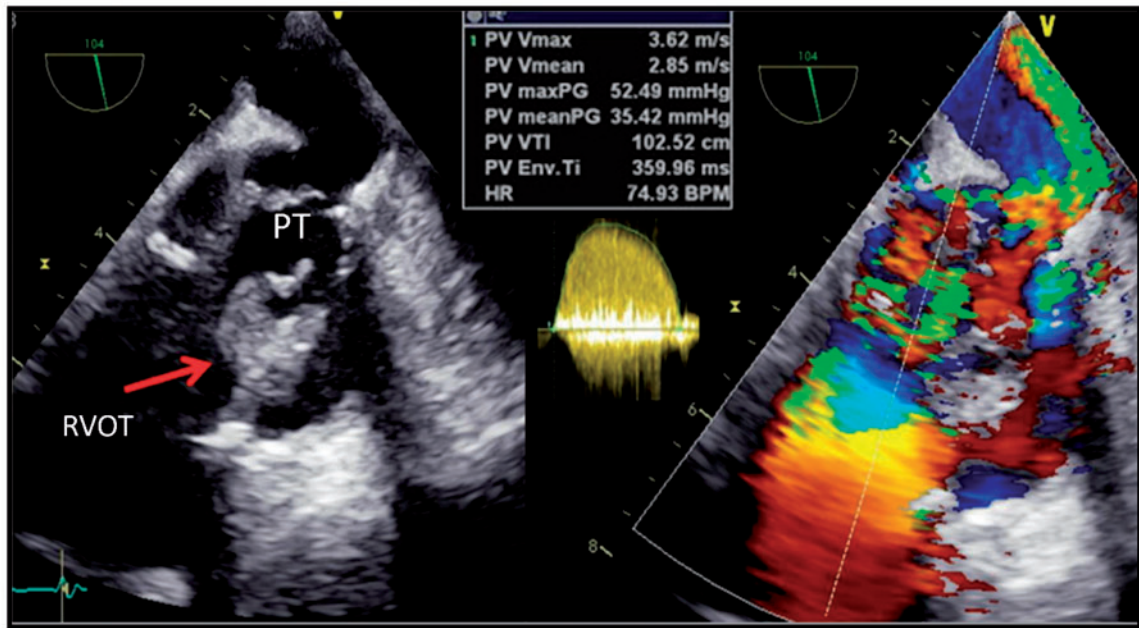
Transoesophageal echocardiogram. Red arrow pointing to a mobile mass arising from the arterial side of the pulmonary prosthesis, extending into the right pulmonary artery and causing right ventricle obstruction; PT, pulmonary trunk; RVOT, right ventricular outflow tract.
